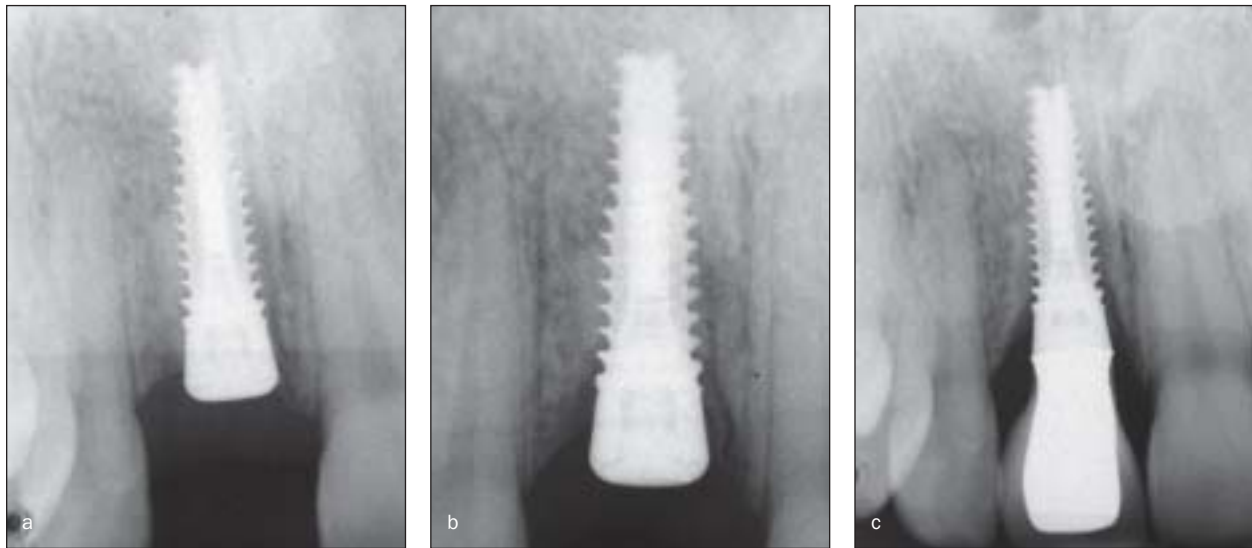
Radiographs showing the course leading to osseodisintegration of the implant in patient 6: (a) immediately after placement; (b) at reentry, immediately before abutment connection, and (c) after failure, immediately before removal.
